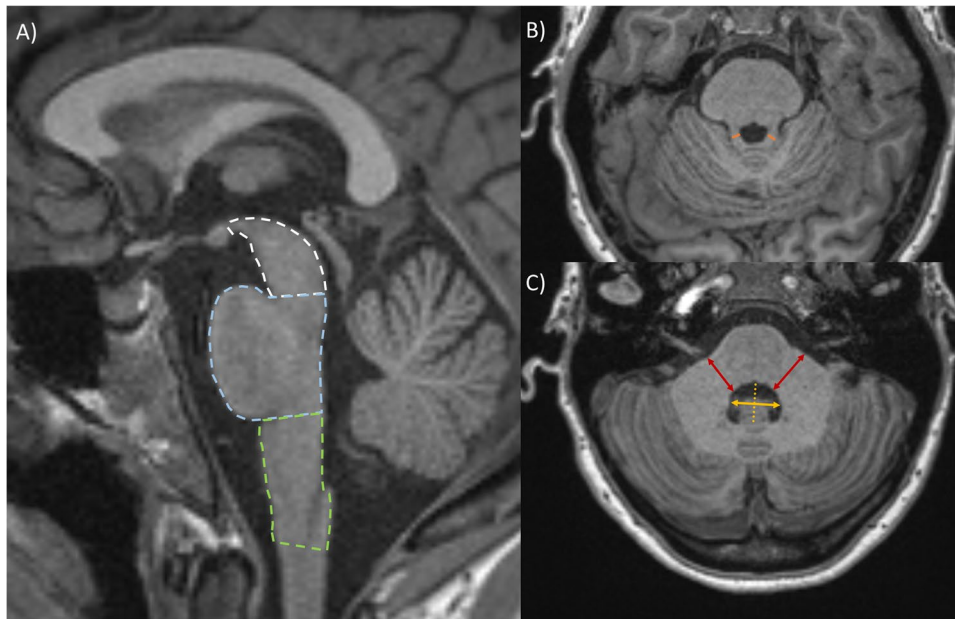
Assessment of brain MR images. A) Representative mid-sagittal T1-weighted image in a control subject. Midbrain, pons, and medulla oblongata areas were delineated manually according to the method described by Oba et al. [16] and Reetz et al. [17]. In short, the caudal edge of midbrain was defined as line passing through the superior pontine notch and the inferior edge of the quadrigeminal plate; caudal edge of pons was defined as a line parallel to the first line passing through the inferior pontine notch; caudal edge of medulla oblongata was delimited along the foramen magnum. The area of the midbrain (excluding the tectum) was traced above the first line (outlined as white dashed line). The area of the pons was traced between the first and second line (outlined as blue dashed line). The medulla
